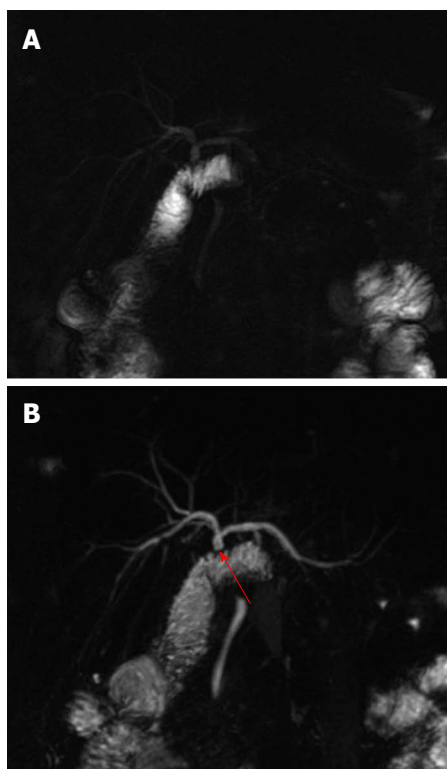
Bilio-enteric anastomosis. A: Single-shot thick-slab magnetic resonance cholangiogram shows a regular hepatico-jejunostomy; B: Maximum intensity projection reconstruction of 3D thin-slab fast spin-echo T2-weighted images confirms the anastomotic patency (red arrow) and better demonstrates the portion of the jejunum and the choledocho of the recipient.
